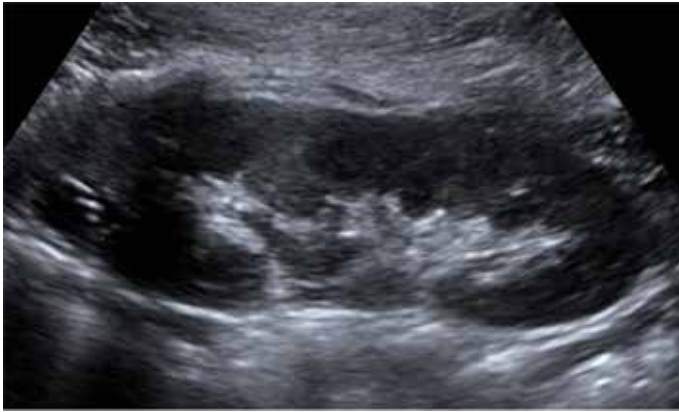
Preoperative ultrasound of the patient's left kidney (sagittal view) showing a 1.6 × 1.1 × 0.9-cm cystic lesion in the upper pole. There is increased echogenicity within the periphery, which may reflect calcifications.
